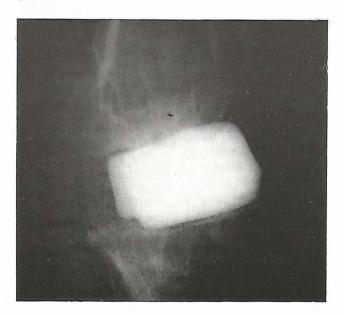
X-rays of knee lateral view after bone cement block.
